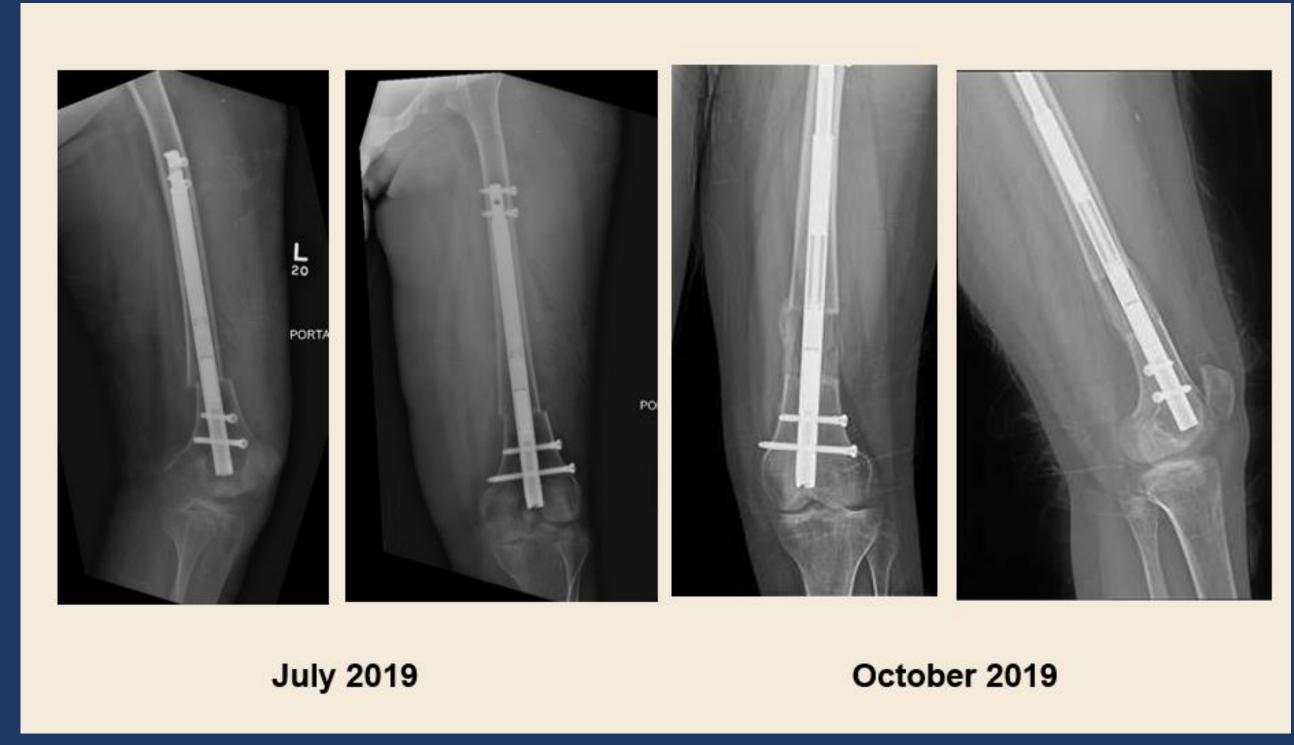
Radiographic images demonstrating initial postoperative and regenerate healing after lengthening.
